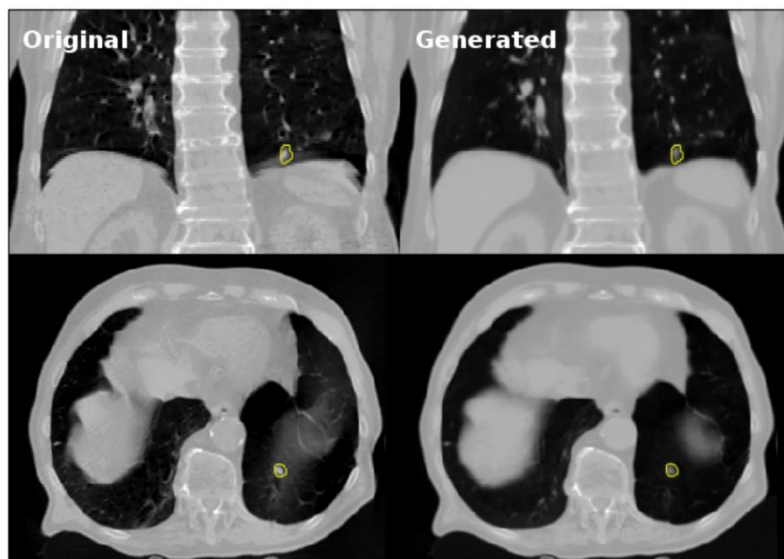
Comparison of the density maps calculated by MCsquare from the 8th phase of the original 4DCT (left) and generated 4DCT (right). The GTV drawn on the original CT phase is displayed in yellow on both images.
